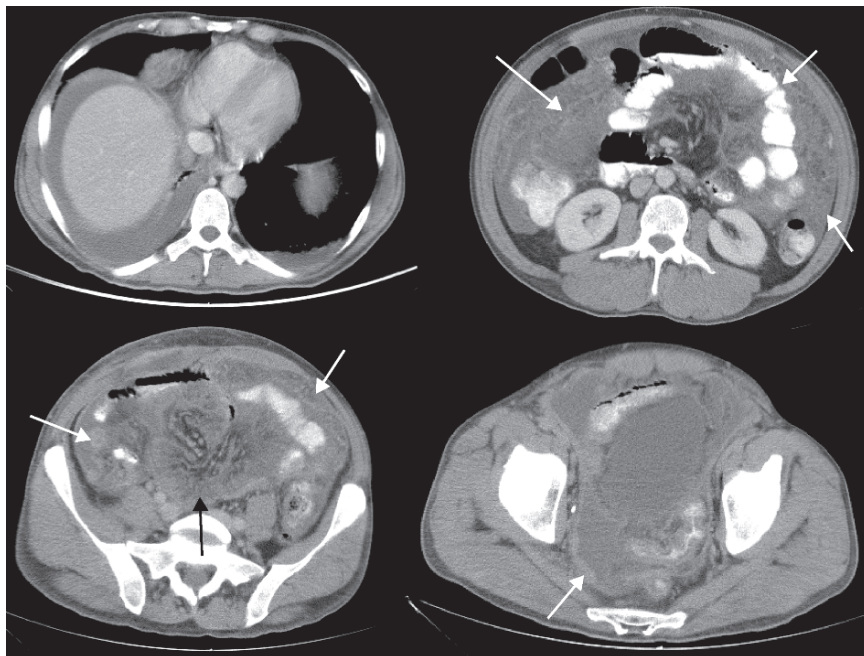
Axial CT images of a 32-year-old patient with a known diagnosis of non-Hodgkin's lymphoma. The image shows nodular and infiltrative involvement of the lymphoma throughout the mesentery
